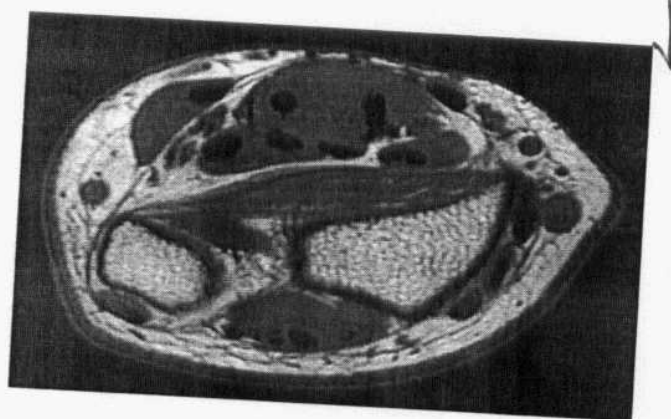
T2-weighted axial MRI taken at the distal forearm show median nerve , ulnar nerve, ulnar artery , radial artery , flexor carpi radialis tendon & flexor carpi ulnaris tendon (*Quoted from Nadja Saupe, et al.,2005*).
